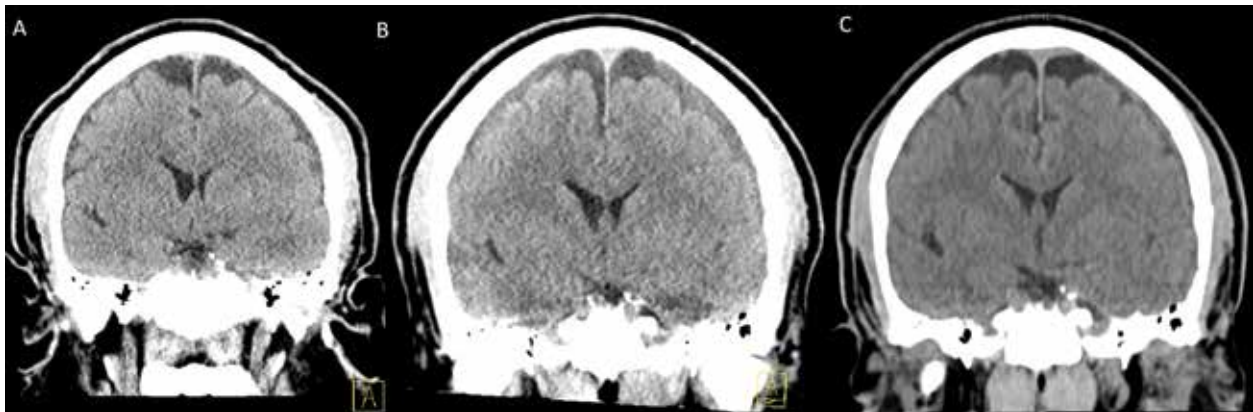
A: CT brain showing bilateral subdural hematomas and possible intracranial hypertension. B: CT brain showing increase in the bilateral subdural collections without acute hemorrhage. C: CT brain showing near-complete resolution of the bilateral convexity subdural fluid collections.
